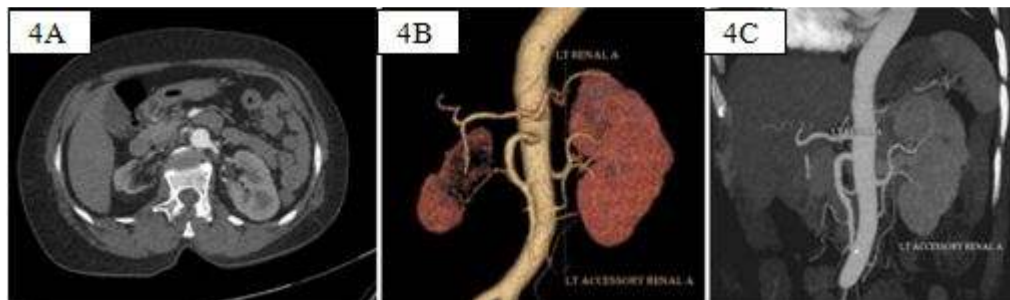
CT renal angiogram done in 80 kV with axial source image (4A), Volume rendered image (4B) and Maximum intensity projection in coronal view (4C)
